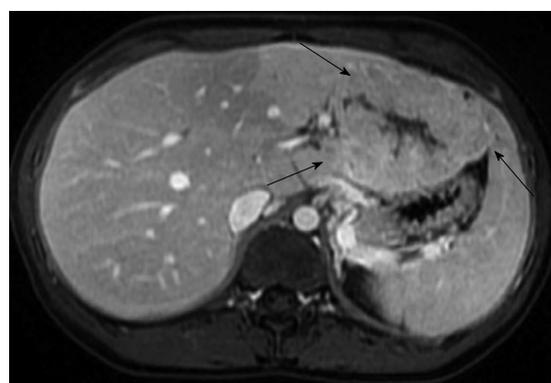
Magnetic resonance imaging of hepatocellular carcinoma in 19-year-old female. Post contrast liver magnetic resonance imaging in portal venous phase shows a large mass (arrows) arising from the left lobe of a liver without cirrhosis. This lesion that has some imaging similarities with focal nodular hyperplasia, corresponded to fibrolamellar carcinoma on pathologic analysis.
